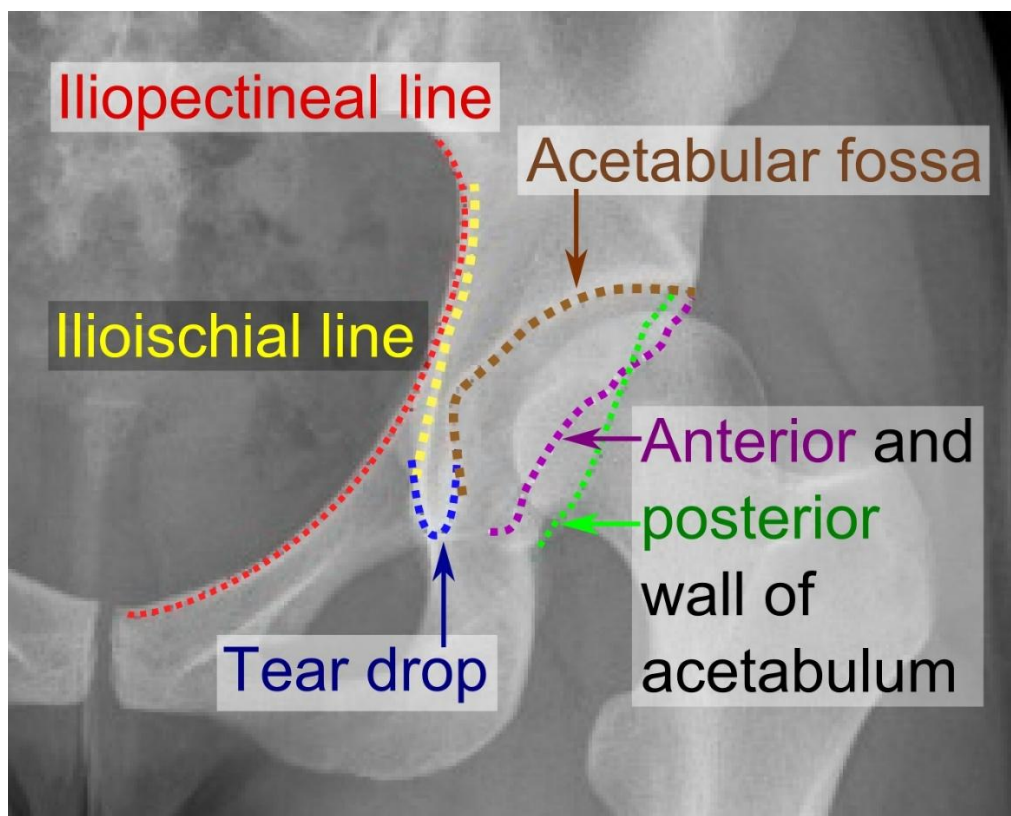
The different lines assessed in an X-ray radiograph in a suspected acetabulum fracture case
